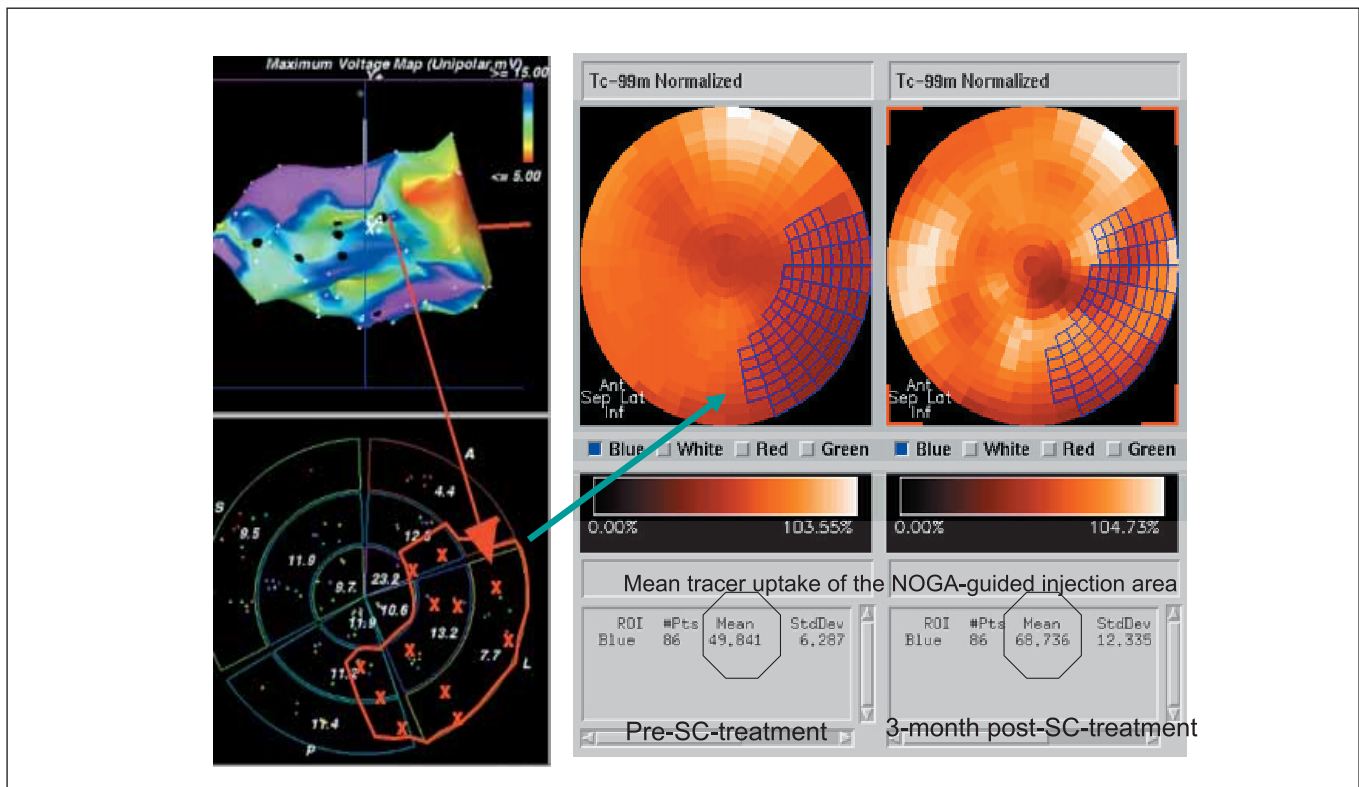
Colour-coded NOGA unipolar voltage image with injection (black) points (left upper panel). Bulls eye view of the NOGA image with delineation of the injected area (region of interest, ROI) (left bottom panel). SPECT image under resting conditions before autologous mononuclear cell (BM-MNC) treatment with the transferred ROI (left scintigraphic polar map) and three months after the cardiac BM-MNC treatment (right scintigraphic polar map), indicating an improvement in mean tracer uptake from 49.8% to 68.7%.
